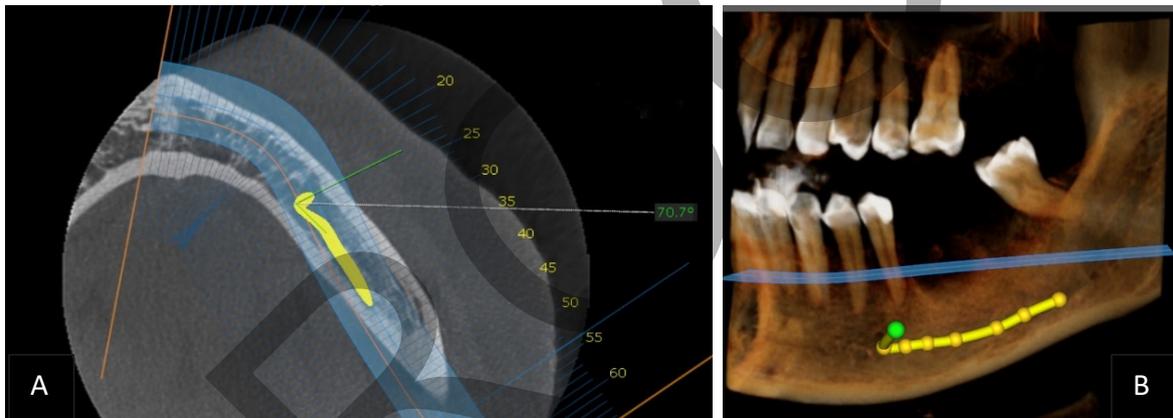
Axial CBCT image (A) and volume rendering image (B) show the anterior loop of the IAN, which in its first part, dips downwards and is then displaced upward and posteriorly with an angle of 70.7 degrees to exit the MF.
